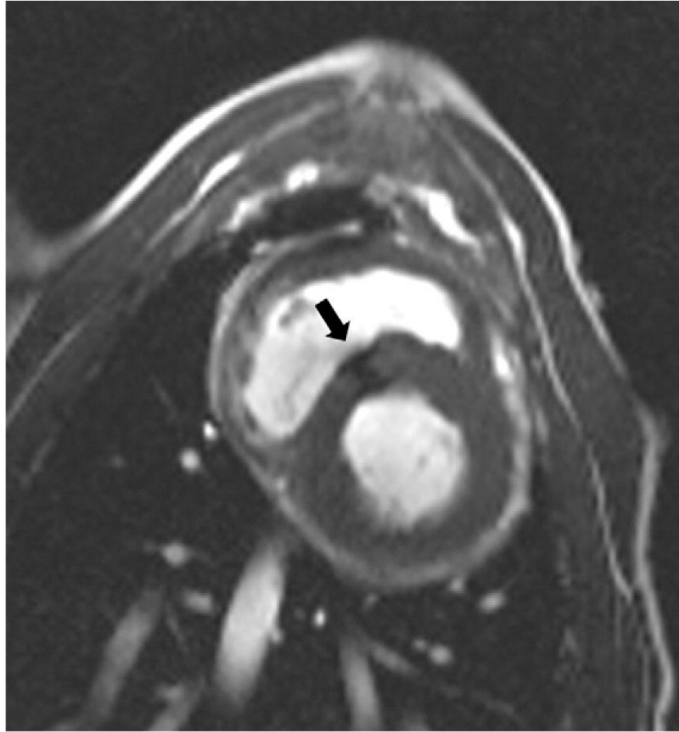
MRI Demonstrating Successful Device Deployment and Right Ventricular Free Wall Closure at 1-Month Follow-Up
